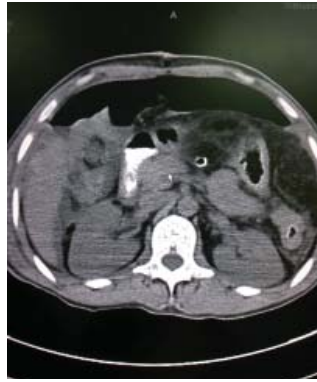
CT abdomen with showing contrast in the duodenum.
